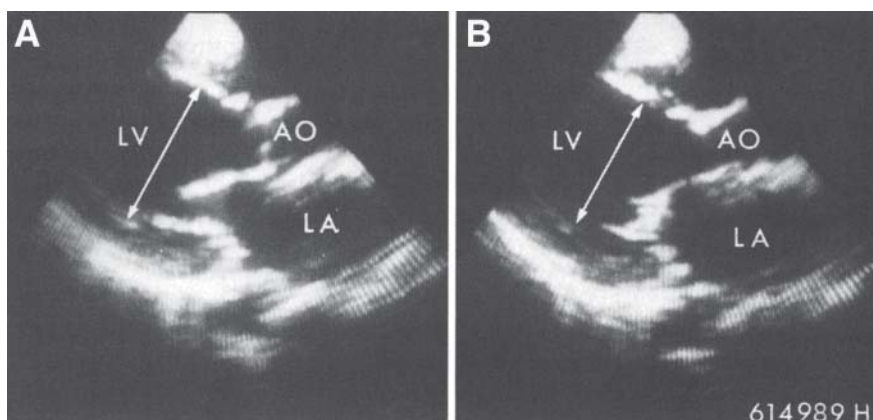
Long-axis parasternal two-dimensional echocardiogram in diastole (A) and systole (B) of a patient with dilated cardiomyopathy. Little difference in the left ventricular diameter exists between the two recordings. The mitral valve opening in (B) is also markedly reduced. LV, left ventricle; AO, aorta; LA, left atrium. From Feigenbaum H. *Echocardiography*. Fourth edition. Philadelphia, PA: Lea & Febiger, 1986:532. Reprinted with permission.
